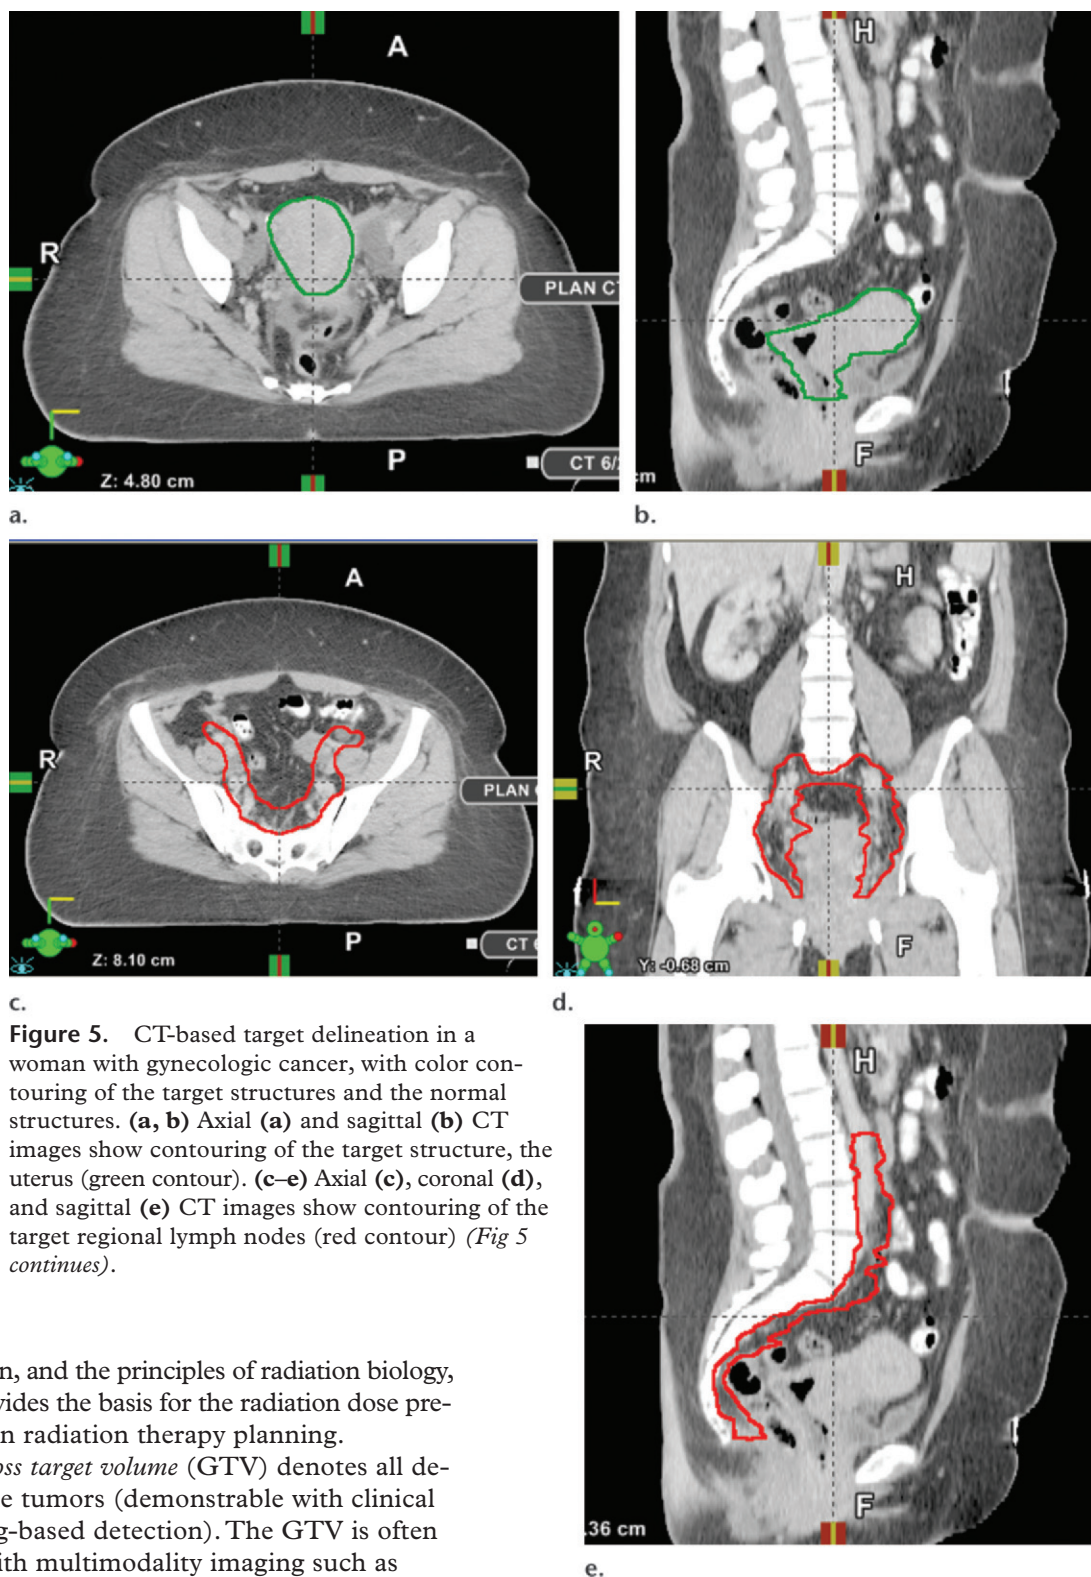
CT-based target delineation in a woman with gynecologic cancer, with color contouring of the target structures and the normal structures. (a, b) Axial (a) and sagittal (b) CT images show contouring of the target structure, the uterus (green contour). (c–e) Axial (c), coronal (d), and sagittal (e) CT images show contouring of the target regional lymph nodes (red contour) (Fig 5 continues).
